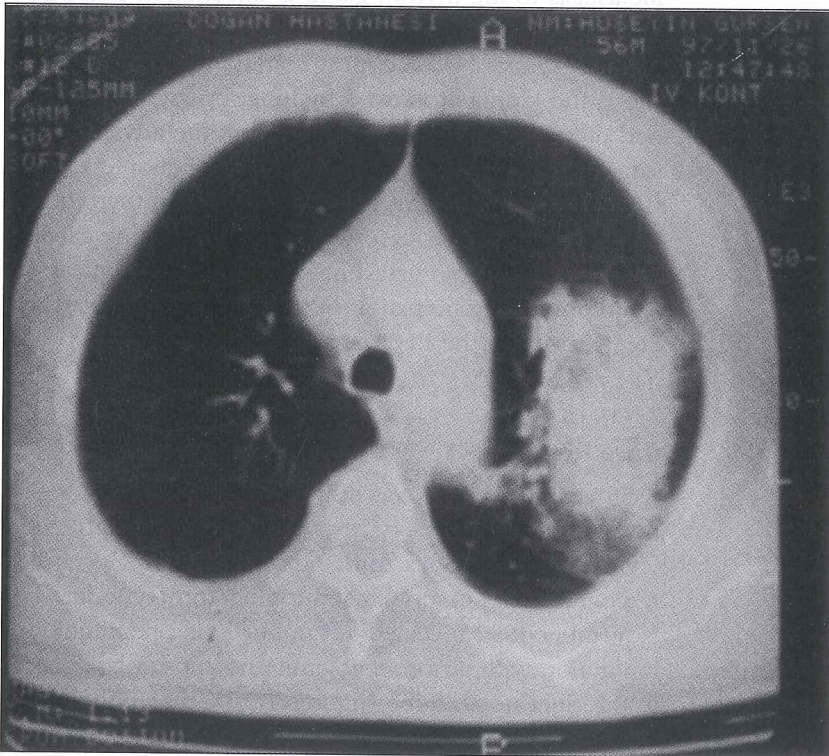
Chest CT on the left upper lobe huge consolidation with peripheral pneumonic infiltration.
